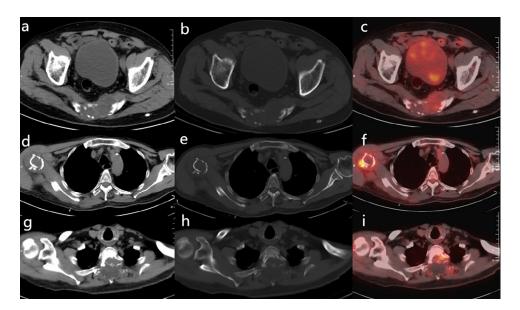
The fluorine-18 fluorodeoxyglucose positron emission tomography-computed tomography images showing multiple osteolytic destructive lesions with increased fluorine-18 fluorodeoxyglucose uptake in the sacrococcygeal region (A-C), the proximal shaft of the right humerus (D-F), and T2 and T3 (G-I).
